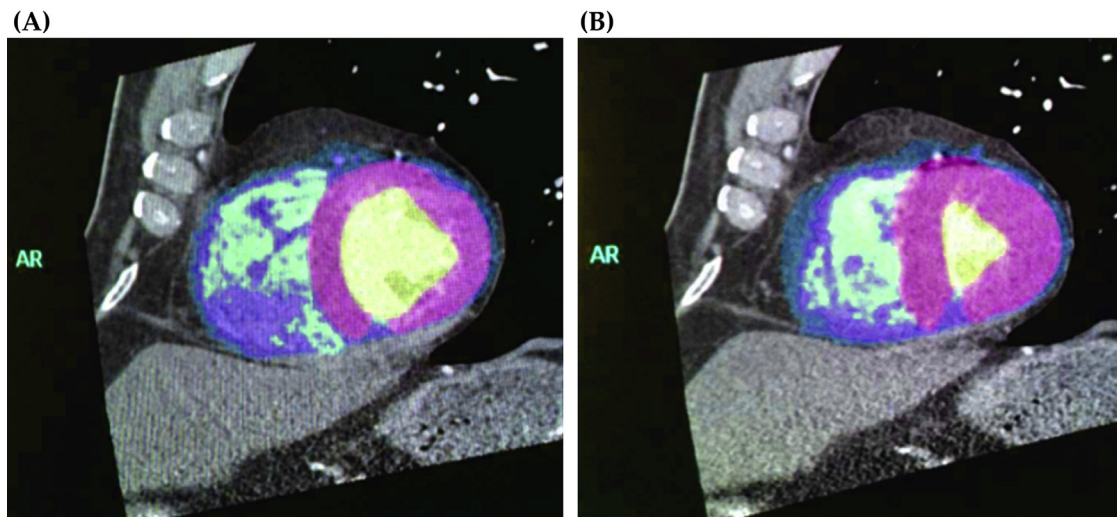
Automatic recognition of the LV endocardial borders and thus the ventricular lumen using a commercial software and cardiac CT angiography. End-diastolic measurements (A) and end-systolic measurements (B) enable the computation of the EF. *Adapted from Singh et al. [136].*
